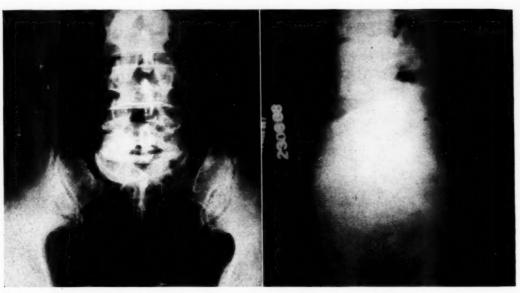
The roentgenograms show narrowing of the intervertebral disk between the fifth lumbar vertebra and the sacrum, and also some change between the fourth and fifth lumbar vertebra.
